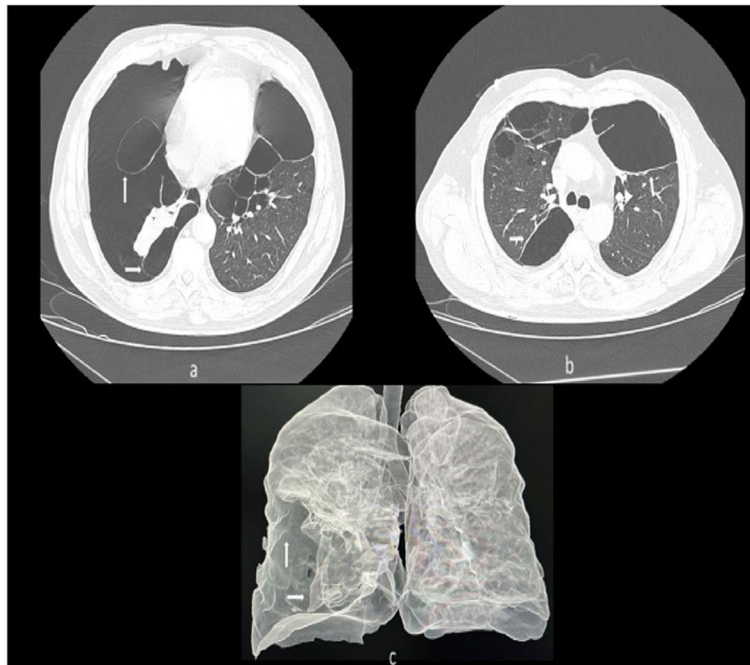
a–c Axial high-resolution computed tomographic images of 59-year-old male patient with severe dyspnea. a Demonstrating double wall sign, with air outlining the wall of the bulla on both the sides and the wall parallel to chest wall suggestive of pneumothorax (white arrow), on right side. b Section taken cranially demonstrating multiple emphysematous bullae with the wall perpendicular to the chest wall and normal adjacent lung tissue in bilateral lungs. c Surface-rendered multiplanar projection reformatted images demonstrating the pneumothorax in right hemithorax compressing the adjacent lung (white arrows). Also, note the rest of the lungs demonstrating bullae with bronchial and vascular markings within
